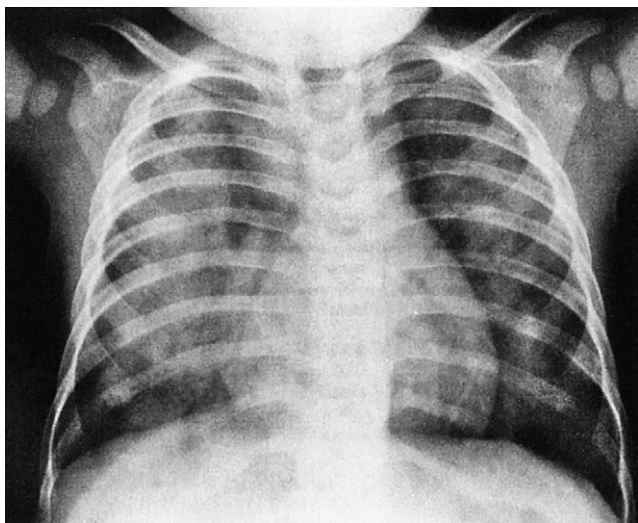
Chest radiograph of a patient with diffuse immune pulmonary hemorrhage.
